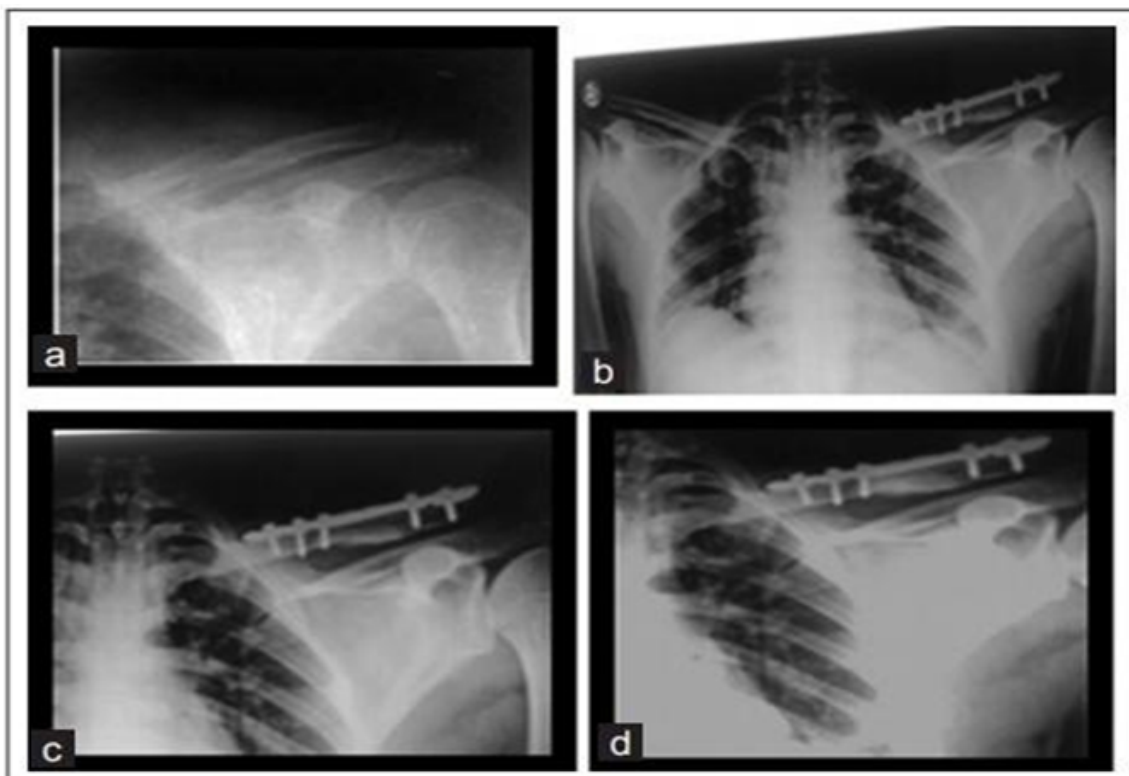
Plate technique (a) Pre-operative X-ray, (b) Immediate post-operative, (c) 3 months post-operative, (d) 12 months post-operative
